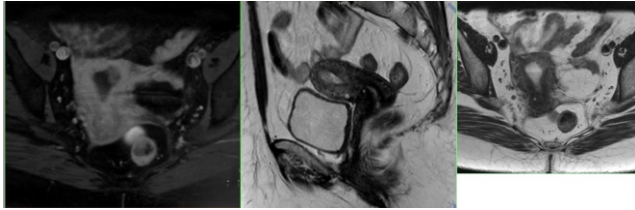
MRI in carcinoma endometrium: Focal hypoenhancing intrauterine lesion is seen along the left cornual surface on post contrast image (left) which shows intermediate signal on T2 weighted sagittal (center) and axial (right) image
